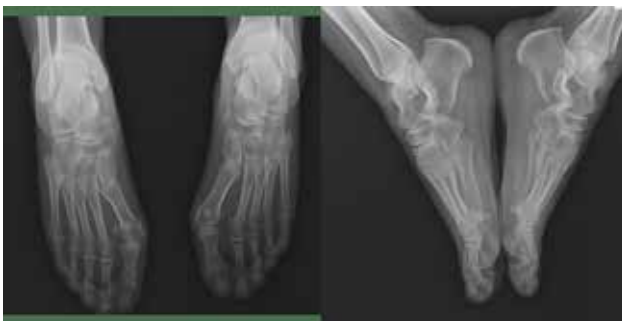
Preoperative radiographic images of a 22-year-old female patient with hallux valgus treated with Kirschner wires.
